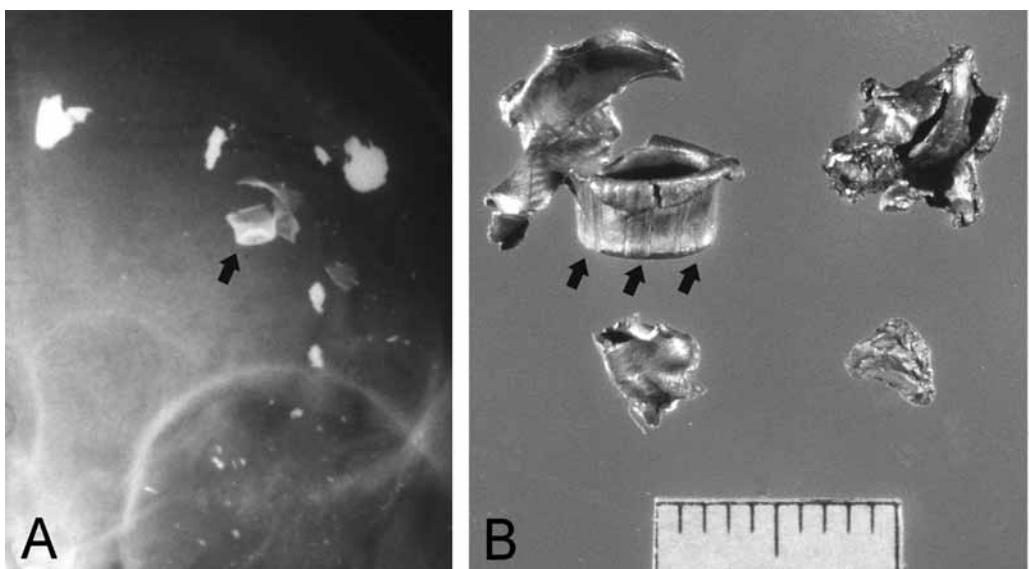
Contact head wound. Partial-jacketed bullet. (A) Jacket (arrow): core separation, seen in radiograph. (B) Removed projectile. The jacket shows visible linear striations (arrows), a general characteristic of the barrel rifling.
